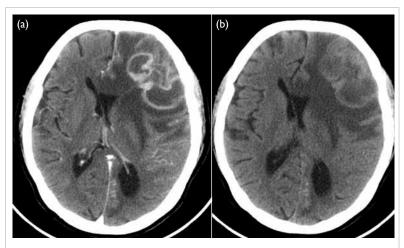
(a) Contrast and (b) plain computed tomography of the brain showing a multilobulated lesion in the left frontal region, measuring 3.9 cm  $\times$  6.4 cm  $\times$  4.7 cm, causing significant mass effect with perifocal oedema, effacement of adjacent sulcal spaces, and resultant right-sided midline shift. It has thin contrast-enhancing rims and non-enhancing central areas. No significant enhancing soft tissue component was associated
